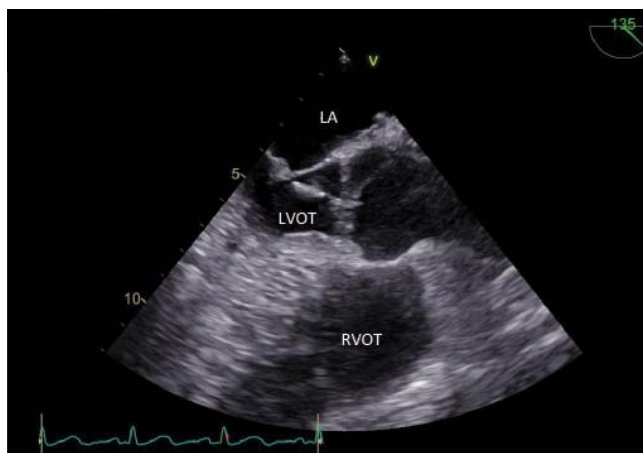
Transesophageal echocardiography aortic valve long-axis view 18 mm long, mobile, hyperechogenic mass attached to the ventricular side of the aortic valve. The echocardiographic appearance is suggestive for vegetation.
